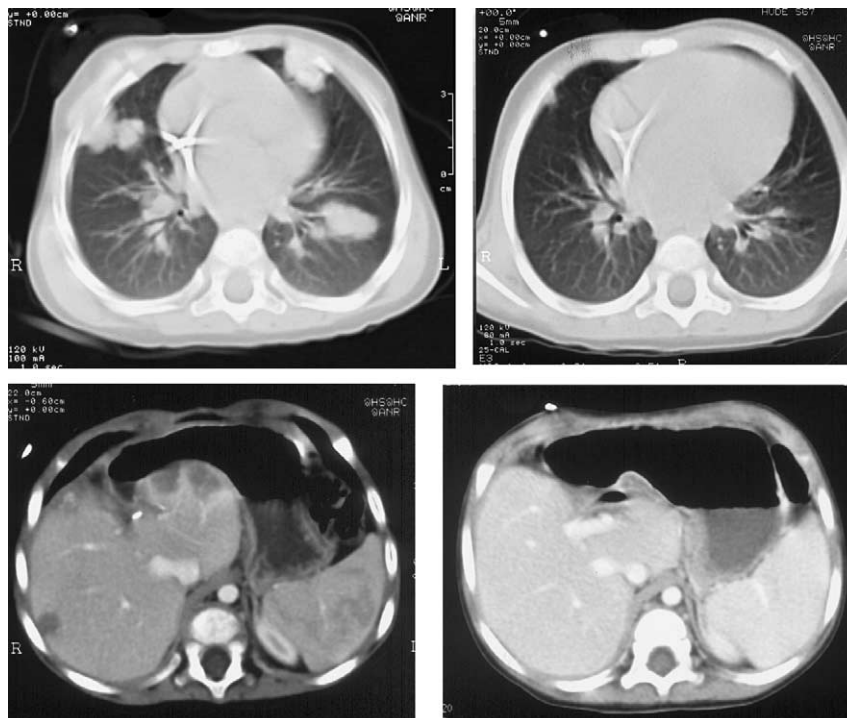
CT scans before and after two courses of high-dose cyclophosphamide in the child who achieved a response.
